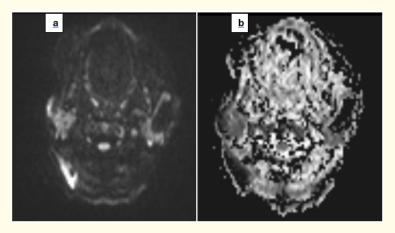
(a) The lesion shows low signal intensity on DWI; (b) Axial ADC mapping image shows hyperintense left parotid mass.
